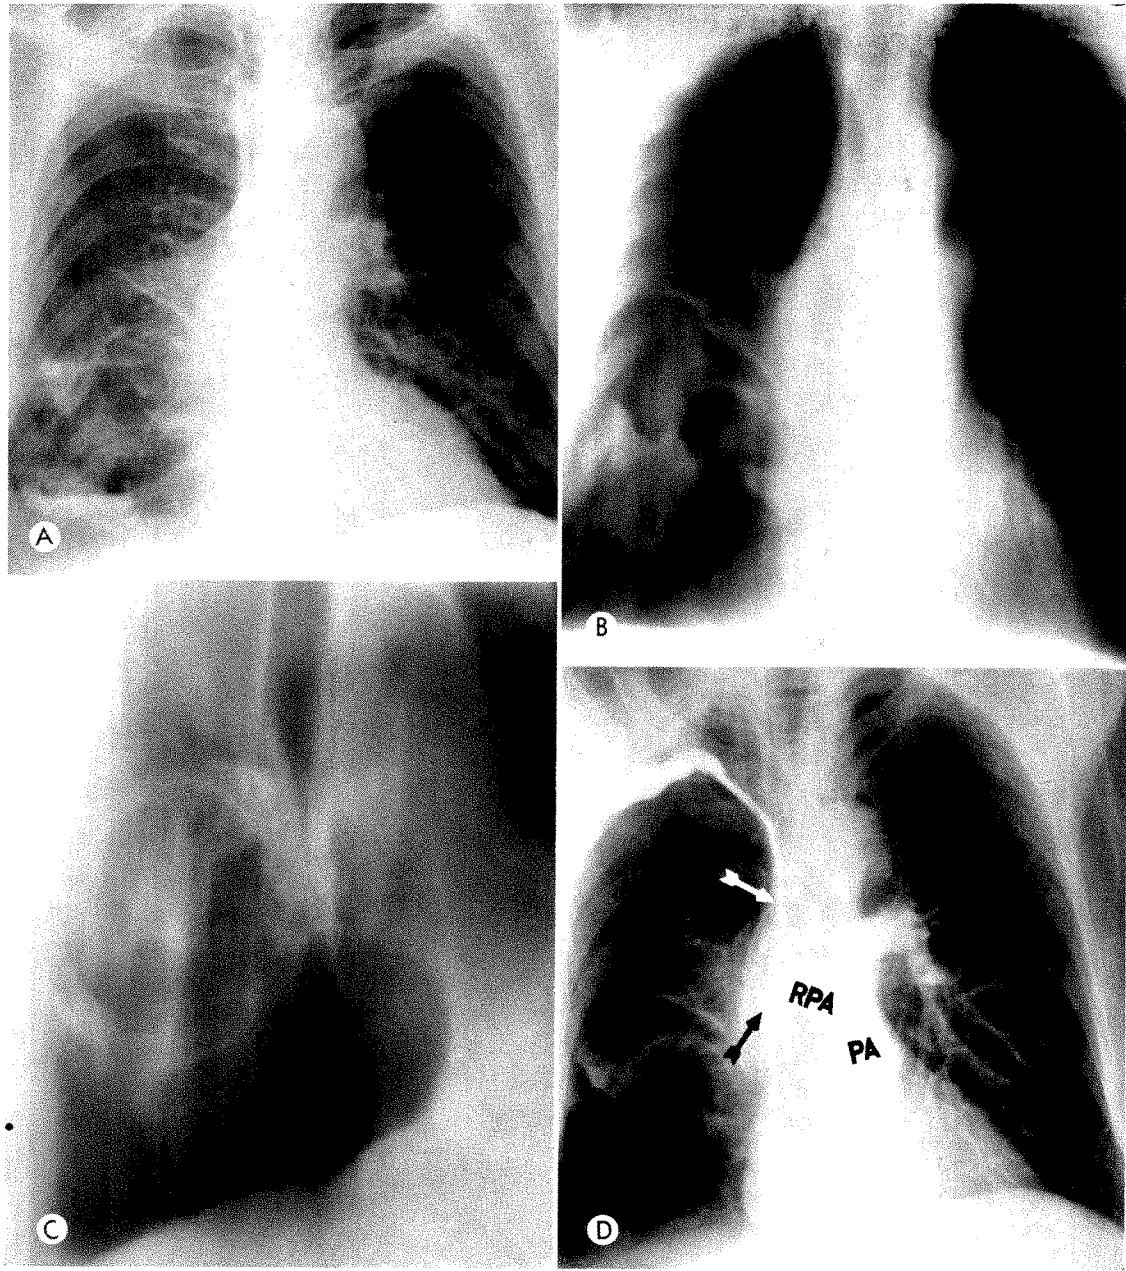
Case VII. *Bullous emphysema of the right lung, improved by pneumonectomy.* (A) Frontal roentgenogram shows multiple bullae of the right lung, especially at the base. (B) Frontal laminagram shows numerous cysts in the right lower lobe. (C) Right lateral laminagram reveals the size of the bullae. (D) Frontal angiogram shows narrowing of the superior vena cava (arrow) and absence of right pulmonary arterial blood flow (arrow). PA is the pulmonary artery and RPA is the right pulmonary artery.
